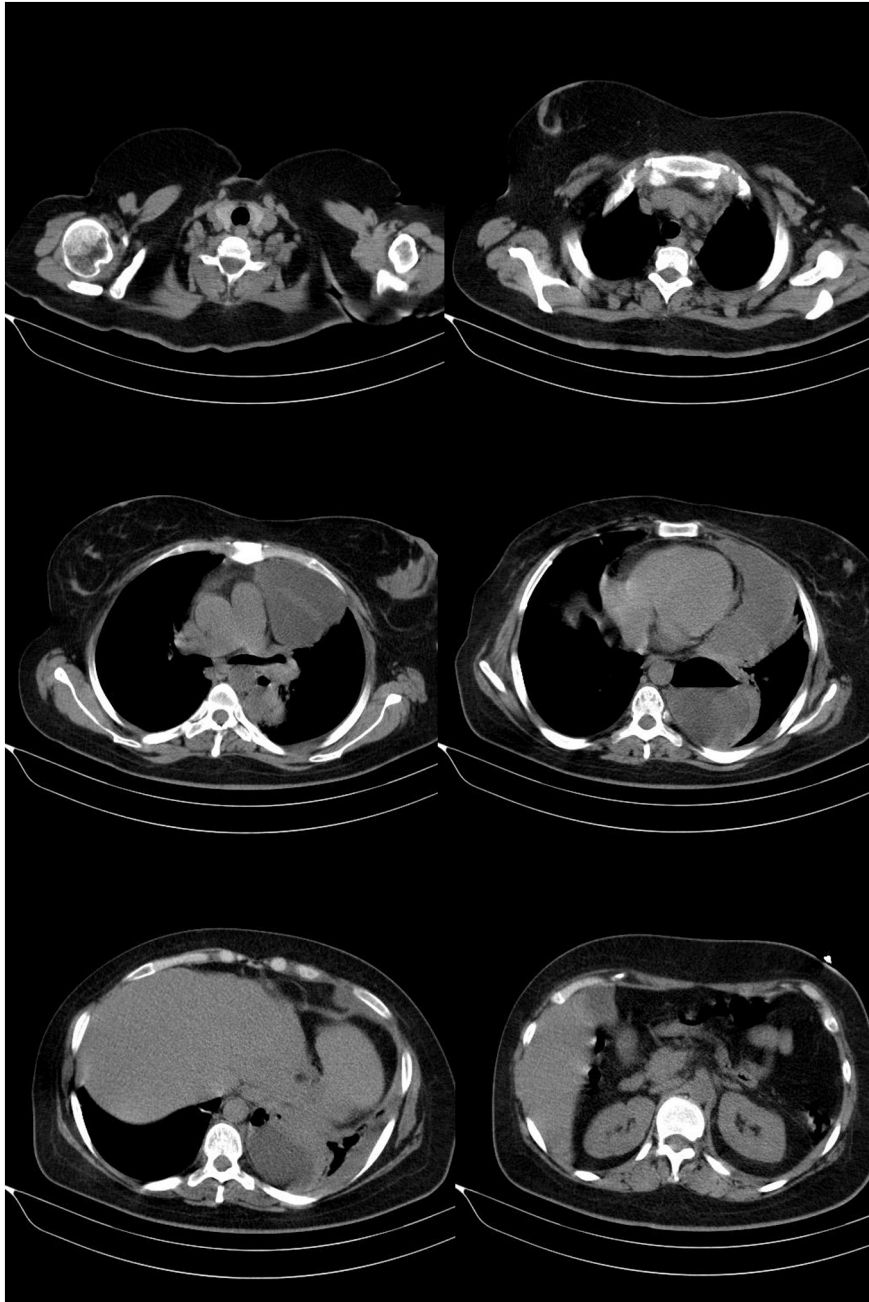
Clinical evaluations of abdomen before diaphragmatic hernia surgery. CT scan thorax and abdomen revealed a Bochdalek hernias.
